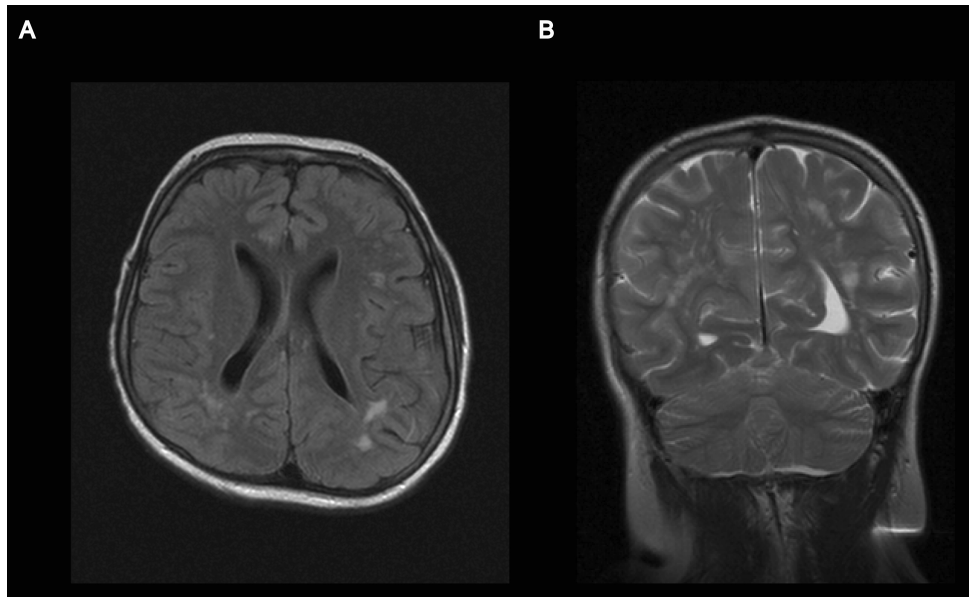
MRI A) Axial FLAIR image at the level of the centrum semiovale, B) Coronal T2 weighted image at the level of the occipital horn of the lateral ventricles, revealing multiple hyperintense lesions in the subcortical white matter of both cerebral hemispheres.
